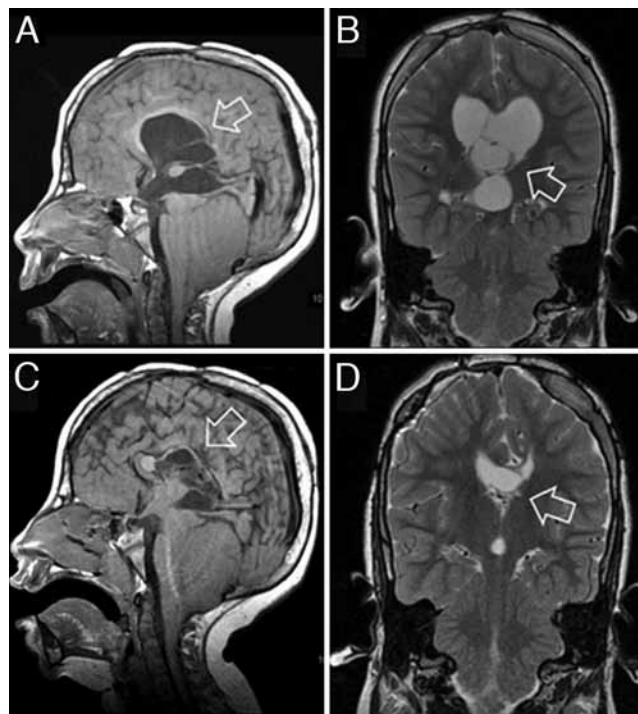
Magnetic resonance images obtained before (A–B) and after (C–D) surgery. Sagittal T1-weighted (A) and coronal T2-weighted (B) images showing cystic dilation of the third ventricle. Herniation of the cerebellar tonsils below the foramen magnum is also visible on the sagittal scan (A). Follow-up sagittal T1-weighted (C) and coronal T2-weighted (D) MR images disclosing a marked reduction in the cystic dilation of the third ventricle. Herniation of the cerebellar tonsils below the foramen magnum is still evident on the sagittal scan (C). Arrow points to dilation of the third ventricle in each panel.
